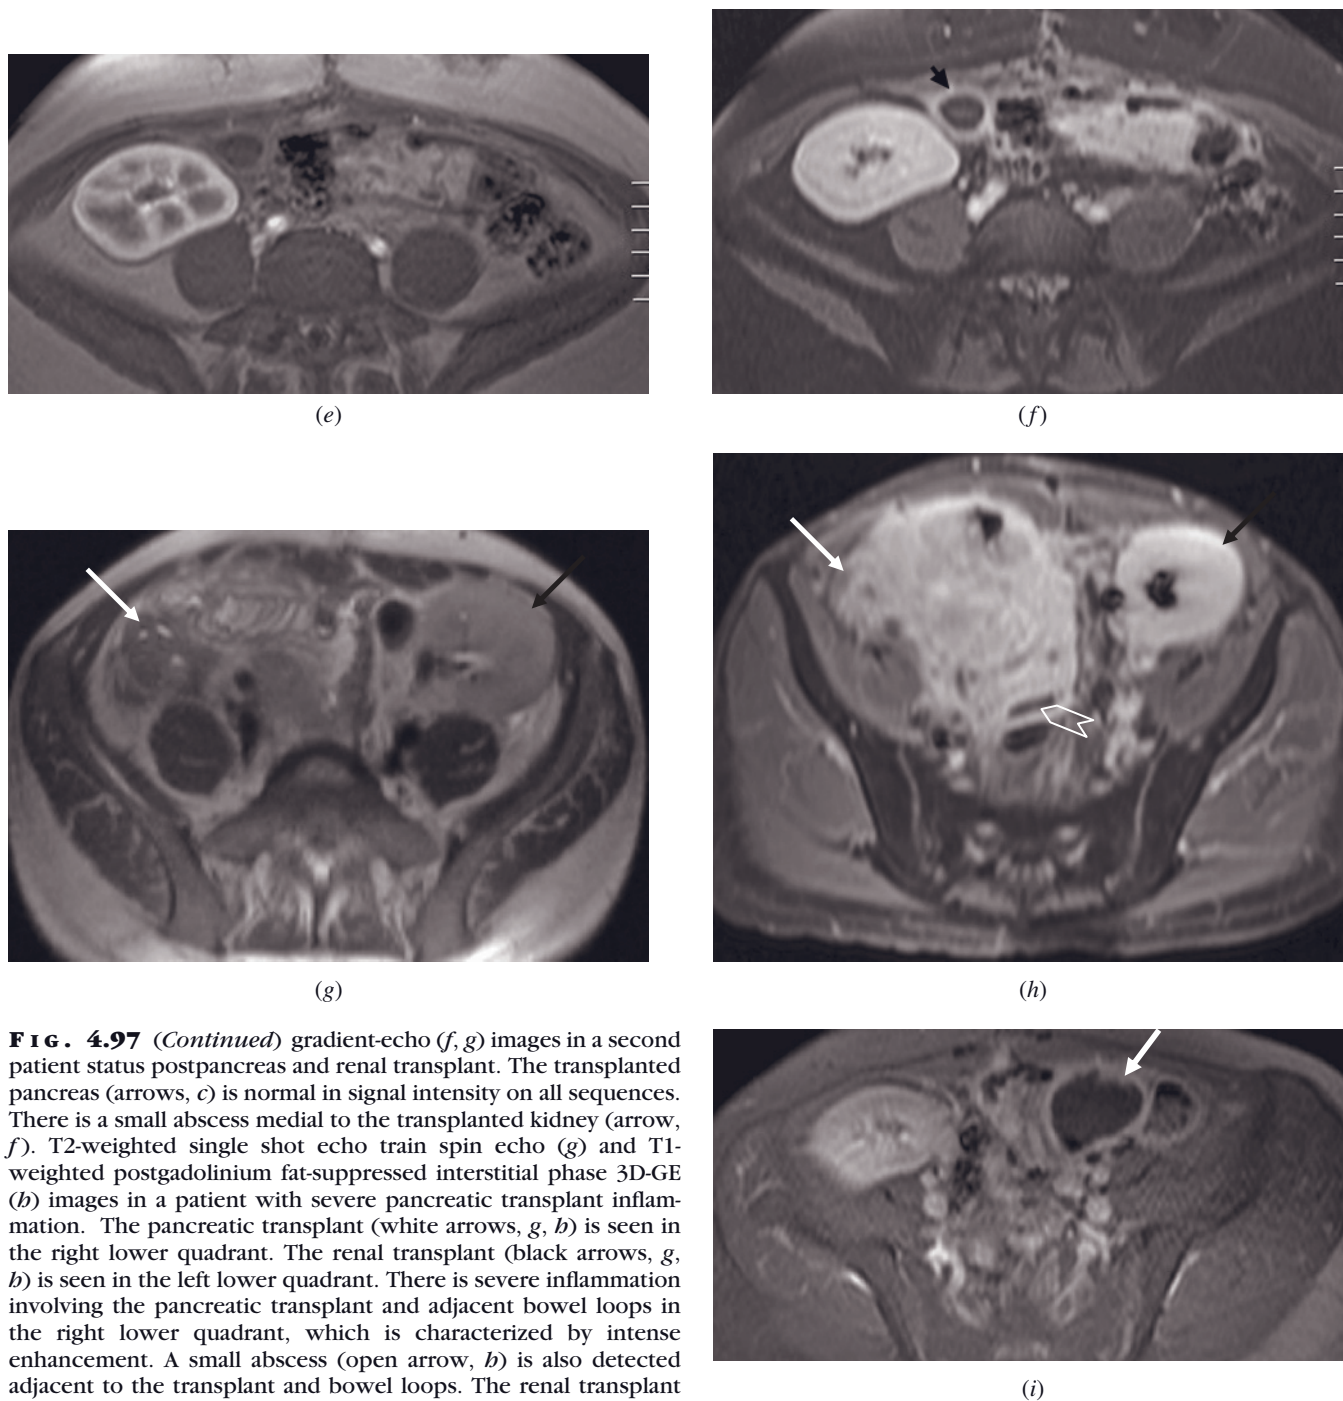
(Continued) gradient-echo (*f*, *g*) images in a second patient status postpancreas and renal transplant. The transplanted pancreas (arrows, *c*) is normal in signal intensity on all sequences. There is a small abscess medial to the transplanted kidney (arrow, *f*). T2-weighted single shot echo train spin echo (*g*) and T1-weighted postgadolinium fat-suppressed interstitial phase 3D-GE (*h*) images in a patient with severe pancreatic transplant inflammation. The pancreatic transplant (white arrows, *g*, *h*) is seen in the right lower quadrant. The renal transplant (black arrows, *g*, *h*) is seen in the left lower quadrant. There is severe inflammation involving the pancreatic transplant and adjacent bowel loops in the right lower quadrant, which is characterized by intense enhancement. A small abscess (open arrow, *h*) is also detected adjacent to the transplant and bowel loops. The renal transplant (black arrow, *g*) is edematous and enlarged. T1-weighted postgadolinium fat-suppressed interstitial phase 3D-GE (*i*) image in another patient with an abscess adjacent to a pancreatic transplant. A large abscess (arrow, *i*) containing free air is detected in the left lower quadrant adjacent to the pancreatic transplant tissue.
